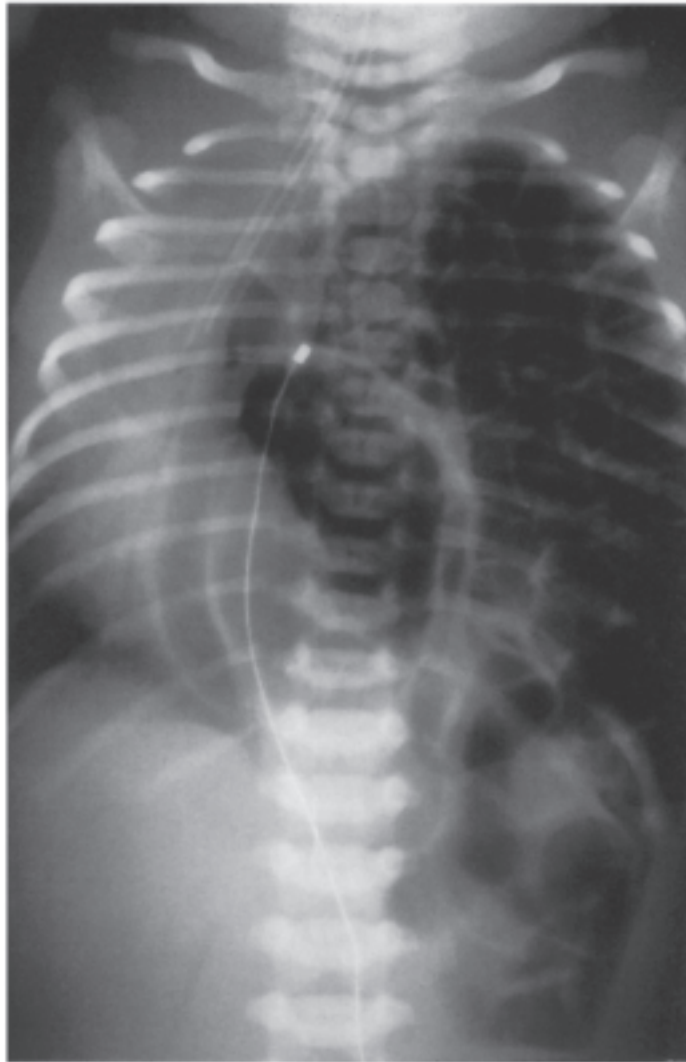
Radiograph showing a left-sided diaphragmatic hernia shortly after birth
